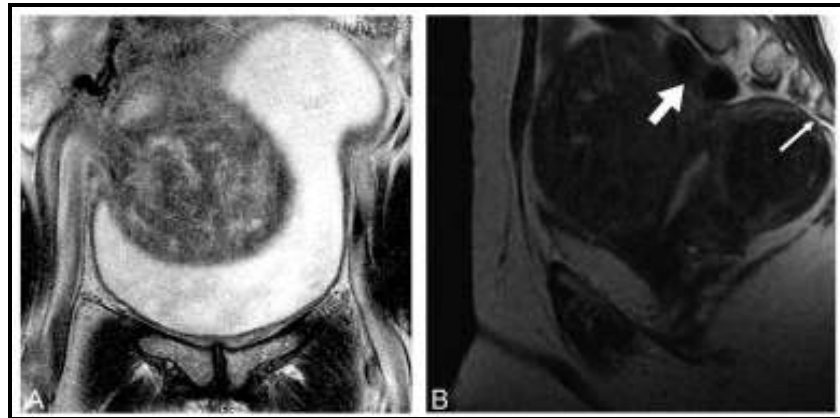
Magnetic resonance imaging (MRI) demonstrating leiomyoma compressing (A) the bladder and (B) the spine (*thin arrow*) and colon (*thick arrow*) (*Laughlin and Stewart, 2011*).
